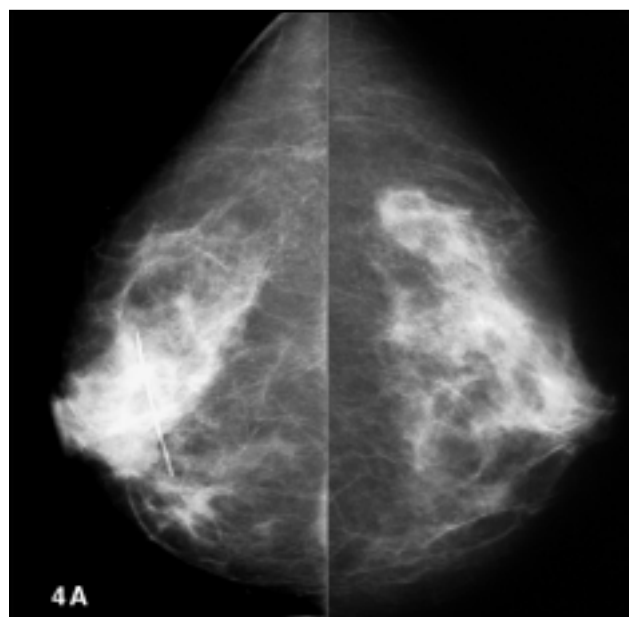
(A) Unremarkable craniocaudal mammogram. T1-weighted axial (B) precontrast, (C) postcontrast, and (D) subtraction images show an occult invasive breast cancer (white arrows) in the right retroareolar tissue of a patient who presented with right axillary lymph node metastases.
